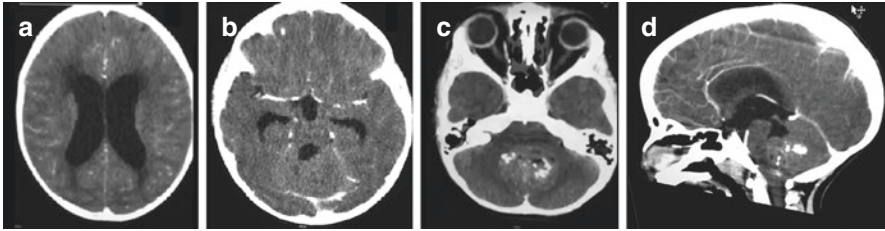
A 6-year-old boy, presenting at the emergency department with vomiting, headache and lethargy, CT scan with contrast showing a non-communicating hydrocephalus. (a) Axial CT, dilation of the frontal horns with transependymal edema. (b) Axial CT, dilation of the temporal horns. (c) Posterior fossa mass with heterogenous contrast enhancement. (d) Sagittal CT, enlargement of the lateral and third ventricles, thinning of the corpus callosum, large mass in the IV ventricle causing an obstruction of the CSF flow through the IV ventricle
